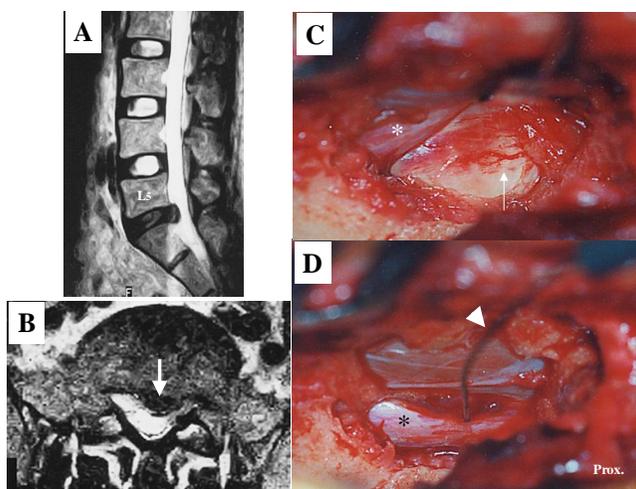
Disc herniation at L5/S1 disc in the reported case. A, MRI. T2-weight (2000/15, Sagittal). B, MRI. T2-weight (2000/15, Axial). ↓: Disc herniation. C, Operative findings. The type of hernia was subligamentous extrusion (Arrow). \*: S1-nerve root. D, The blood flow sensor (arrow head) was inserted into S1-nerve root (\*) above the hernia.
